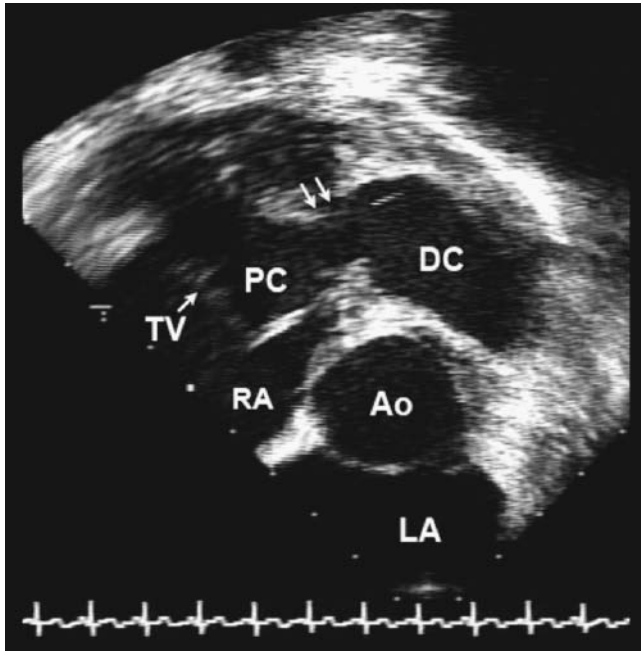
Transesophageal echocardiographic view at the base of the heart showing hypertrophy of the right ventricular wall as noted in this example of a double chambered right ventricle (DCRV) with a proximal high-pressure (PC) and distal low-pressure (DC) chambers. Ao, aorta; LA, left atrium; RA, right atrium; TV, tricuspid valve.
